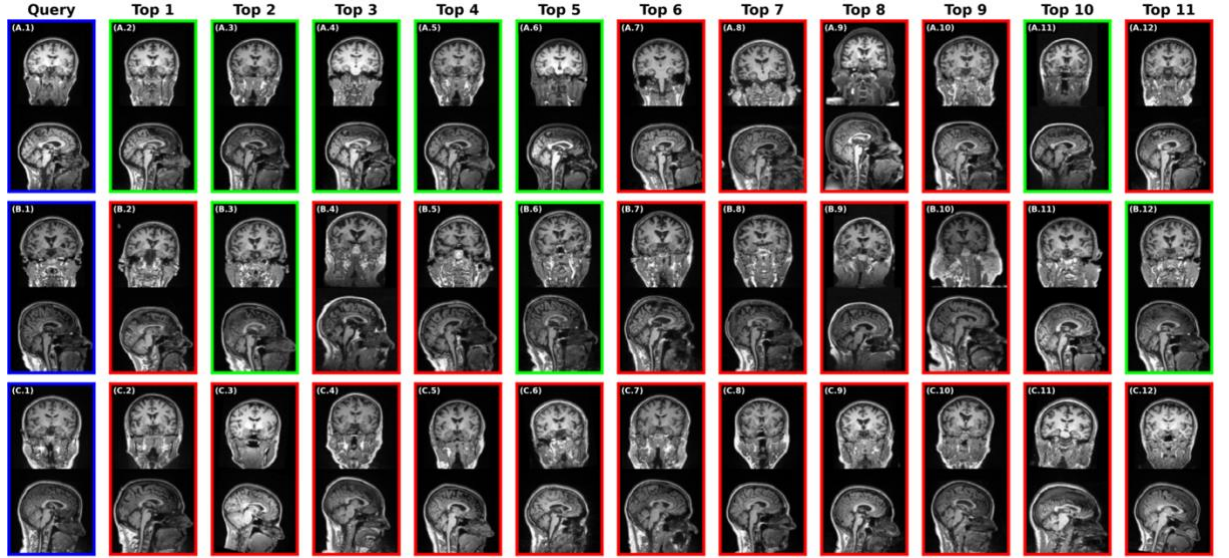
Qualitative retrieval examples for T1-weighted brain MRI scans. For each row, the first column shows the query scan, followed by the retrieved scans ranked from Top 1 to Top 11. A.1 corresponds to a subject with 7 available MRI scans, B.1 to a subject with 7 scans, and C.1 to a subject with 4 scans. The blue border marks the query, green borders indicate correct matches from the same subject, and red borders indicate scans from different subjects retrieved as visually similar.
